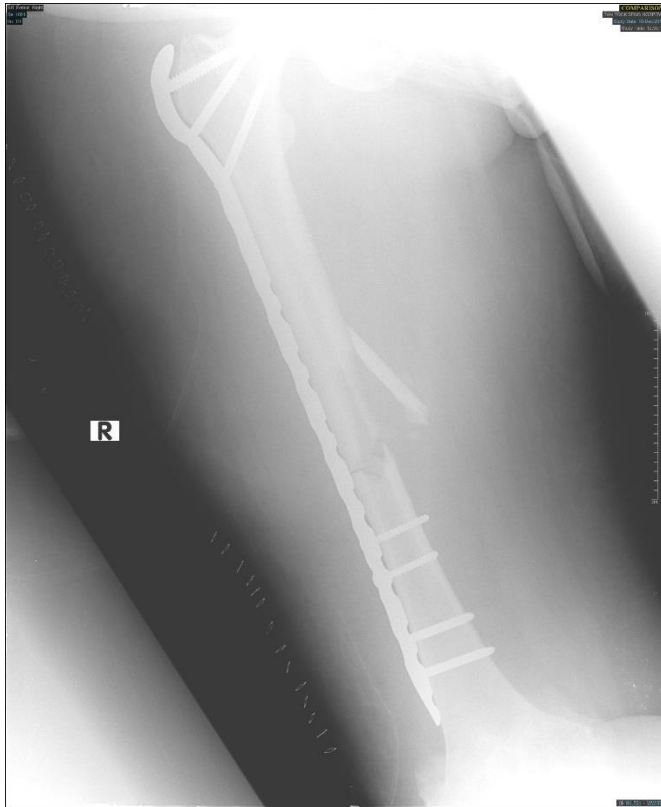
Anteroposterior radiograph shows the right femur after index right femur bridge plating.
